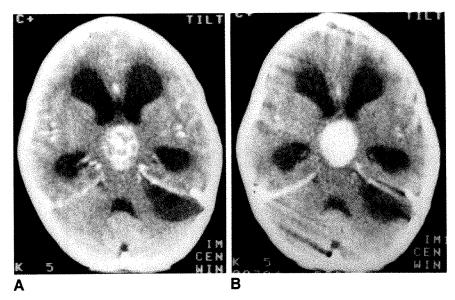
A, Immediate contrast-enhanced CT scan shows multiple microcysts within chiasmal pilocytic astrocytoma. Also noted is arachnoid cyst (asterisk).
